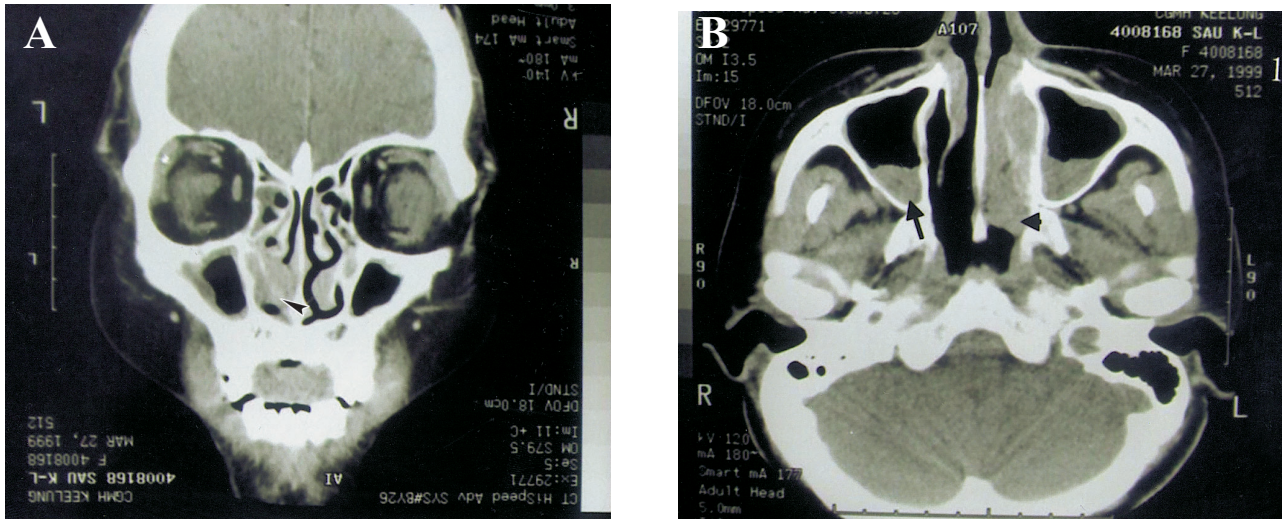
(A) Computed tomography of the head and neck showing a left-side soft-tissue mass on the inferior turbinate (arrow). Maxillary sinus mucosa thickening and cloudiness of the ethmoid sinuses can also be noted. (B) Computed tomography of head and neck in axial view revealing a left turbinate tumor mass (arrowhead) and the maxillary sinus air-fluid level (arrow), suggesting acute sinusitis.
